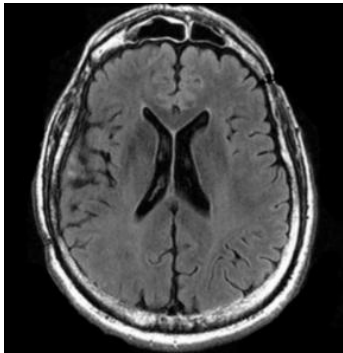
Brain MR image with tumour
